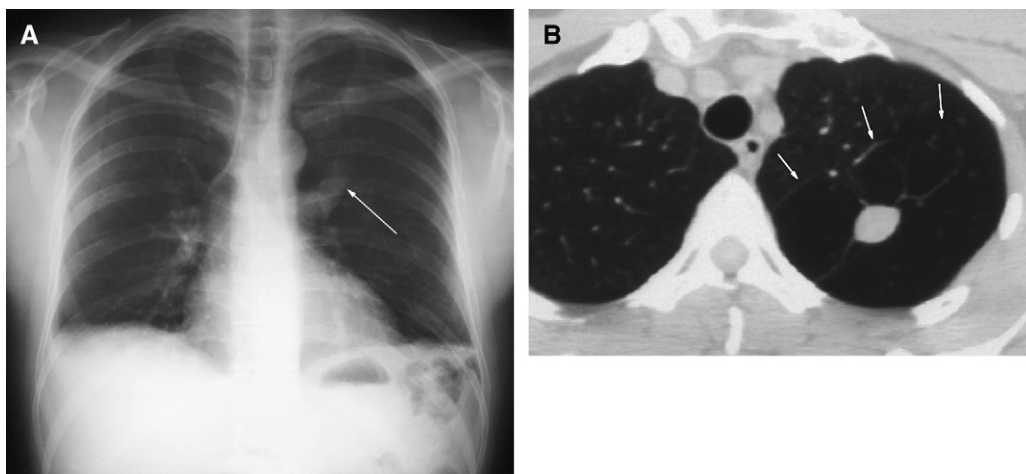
An asymptomatic 34-year-old man with no chest symptoms. (A) Chest radiograph, showing left upper-lobe hyperexpansion and a central ovoid mass (arrow). (B) Transaxial CT image, showing a dilated mucus-filled bronchus and peripheral emphysematous lung (delineated by arrows).
